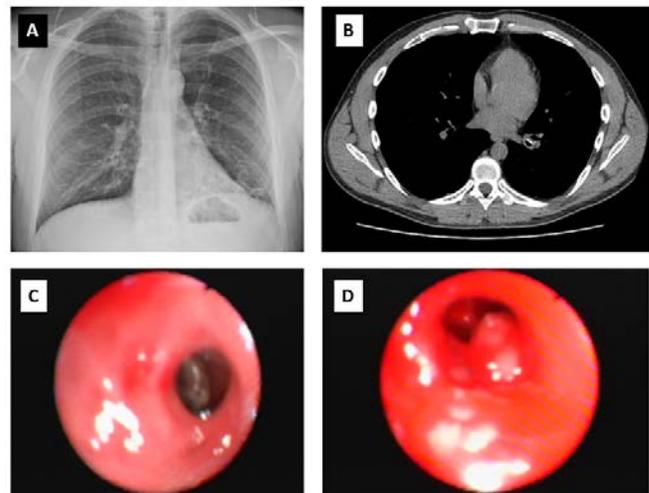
36-year-old male patient with normal chest x-ray (A), thoracic computerized tomography demonstrating foreign body (FB) within left lower lobe (B), appearance of FB during rigid bronchoscopy (C), chronic granulation tissue formation at site of removed FB (D)
